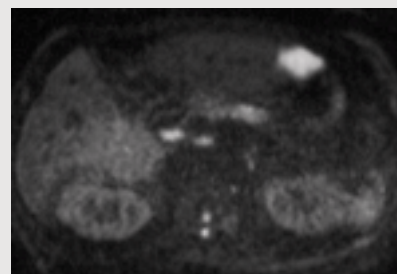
10 Diffusion-weighted image – DWI ($b = 1000$)
